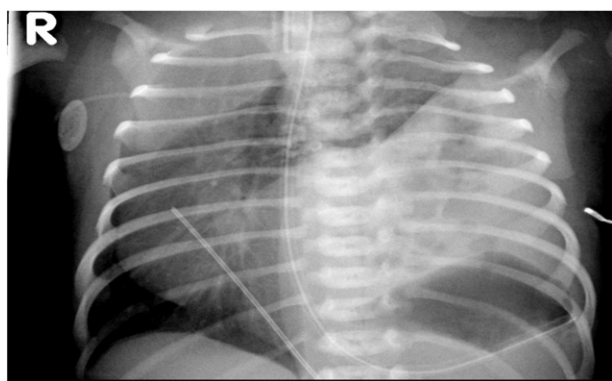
Initial chest x-ray showing bowel gas pattern in the left hemithorax with mediastinal shift to the right consistent with CDH.
